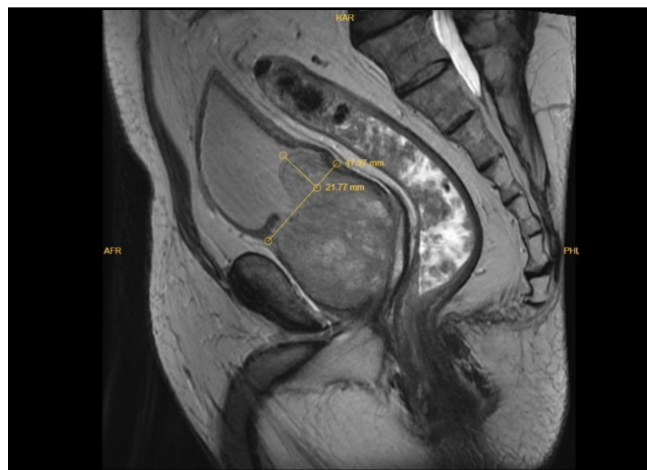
Prostate MRI sagittal section image, IPP measurement
